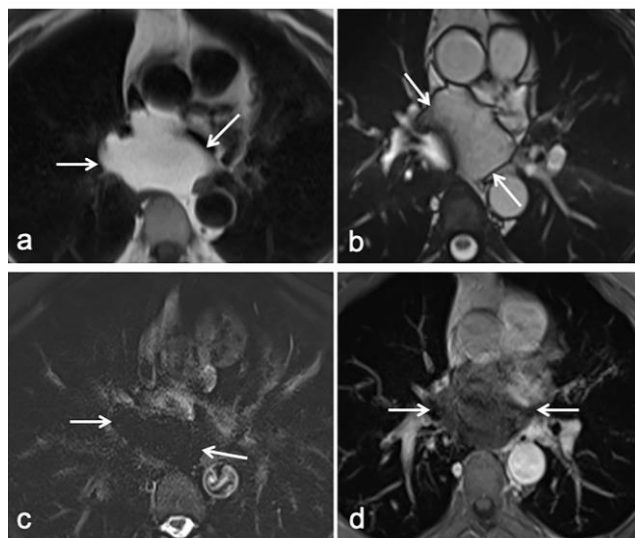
Cardiac MRI. Axial T1-weighted (a) and T2-weighted (b) images revealing a well-circumscribed hyperintense mass. On fat-suppressed axial T1 (c), the lesion becomes hypointense with marked signal drop, consistent with fat. The mass measures approximately 6 × 5 × 8 cm. Postcontrast axial T1 (d) revealing no pathological enhancement, supporting the diagnosis of lipoma.
